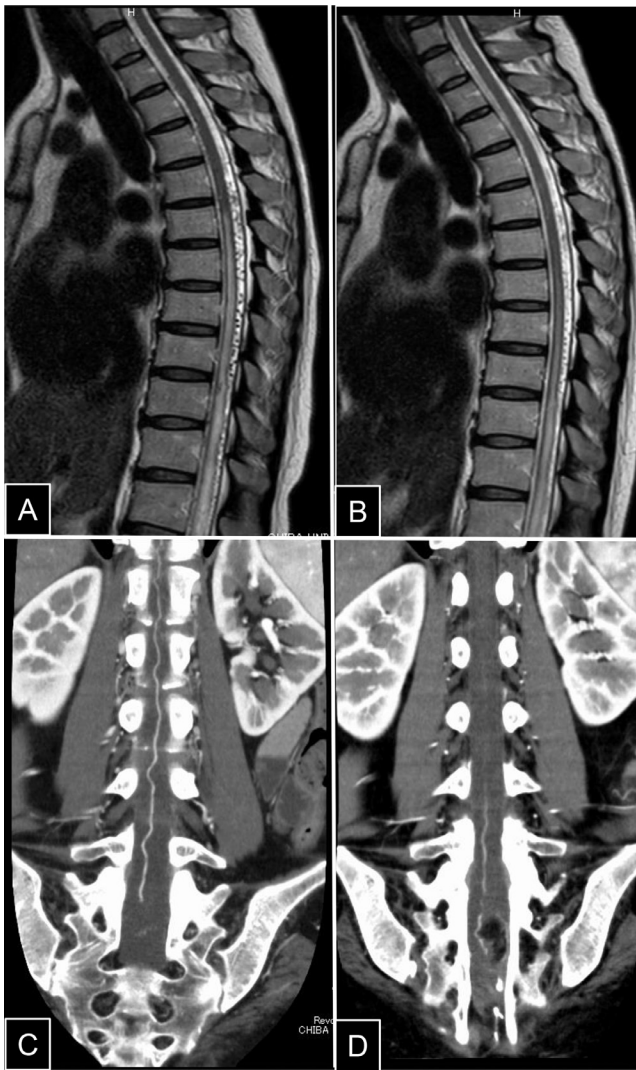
The upper row shows T2WI of MR imaging preoperatively (A), 2 days postoperatively (B), respectively. The lower rows are contrast-enhanced CT images preoperatively (C), 3 days postoperatively (D), respectively.
